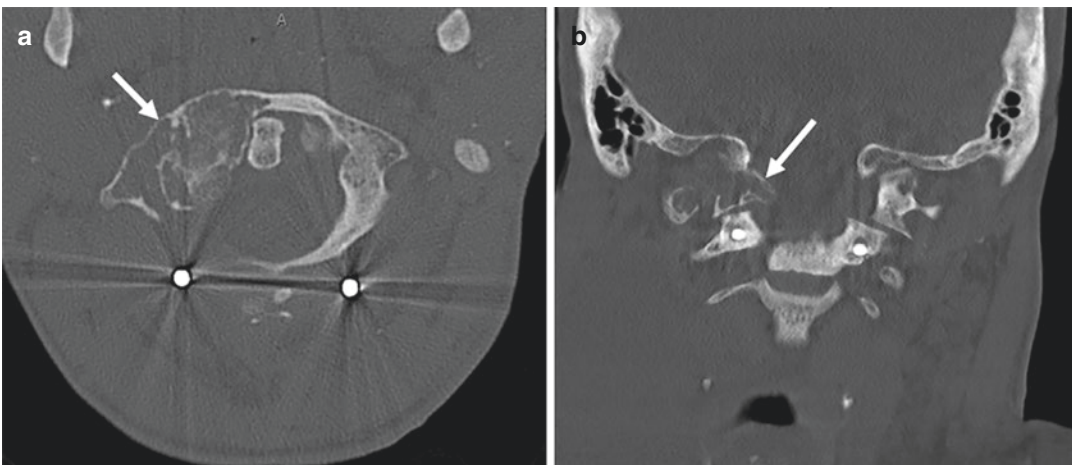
Brown tumor. Axial (a) and sagittal (b) CT of the craniocervical junction demonstrates a lytic, expansile bone lesion (arrow) centered in the right lateral mass. This
